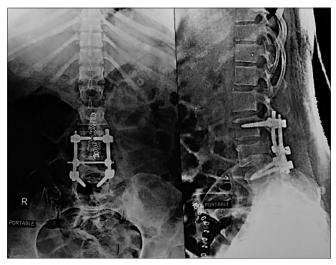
Postoperative X-ray of the lumbosacral spine anteroposterior and lateral view
